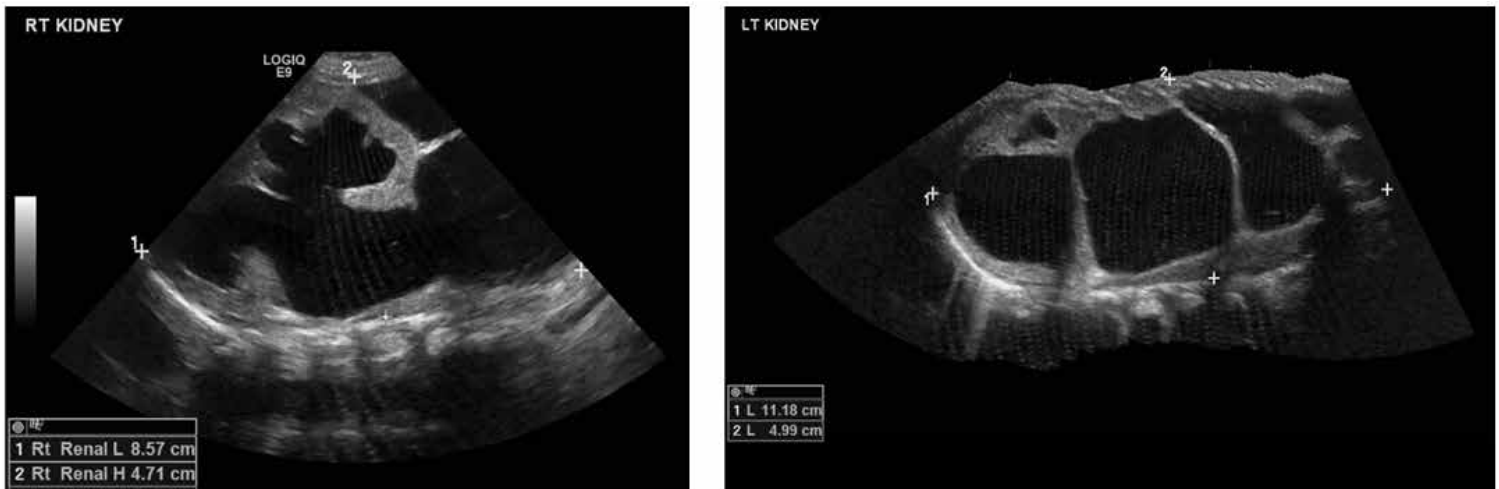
Renal ultrasound showing hydronephrosis
